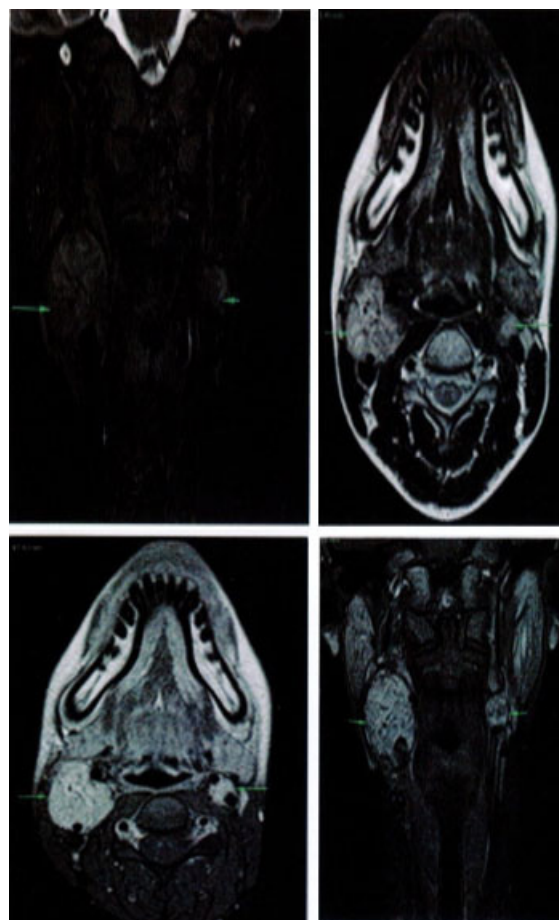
MRI, two well-demarcated tissue masses with a “salt and pepper” appearance.
